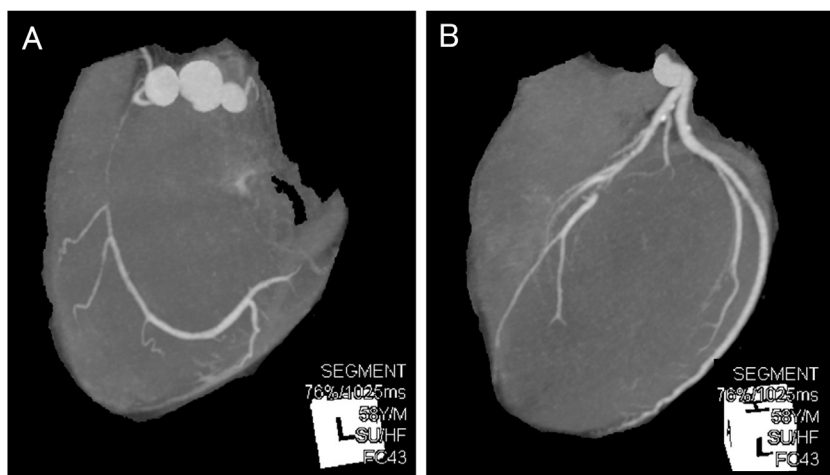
Coronary computed tomography. (A) Severe coronary stenosis in the proximal right coronary artery. (B) Chronic total occlusion of the mid left anterior descending coronary artery with bridging collaterals.
